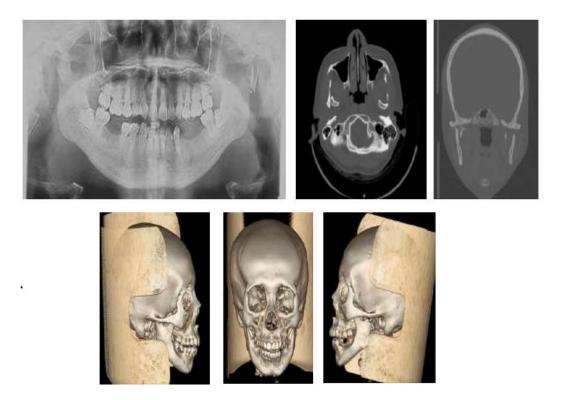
Panoramic radiograph and 3D CT scan of bilateral condylar fractures.
